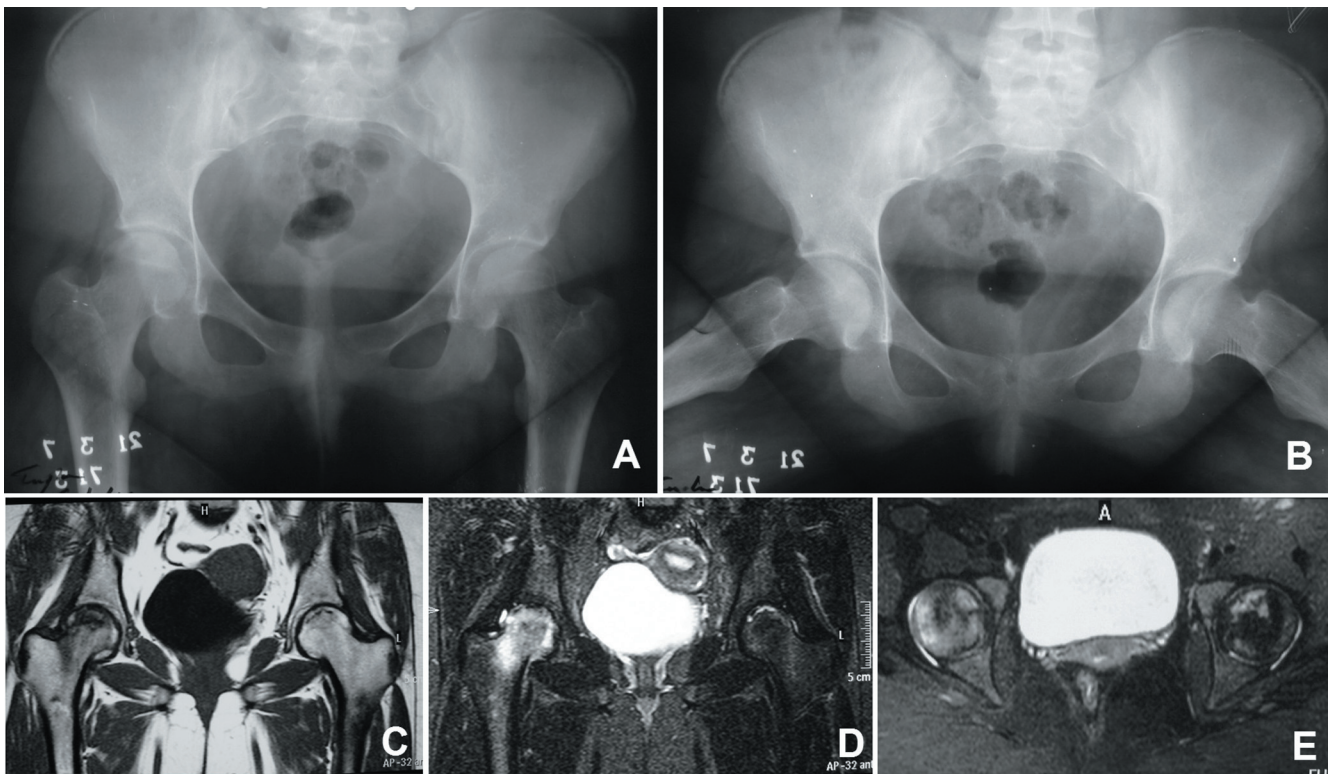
A-E. Anteroposterior (a) and frog-leg (b) radiographs of the pelvis of an 18-year-old female patient (6th patient in Table 1) before the operation show minimal lucent and sclerotic lesions on the right hip with no radiographic changes on the left hip. T1-weighted coronal MRI scan (c) demonstrates low signal intensity in the superior weight-bearing area of the right femoral head. There is also a low signal intensity rim in the proximal aspect of the left femoral head. T2-weighted coronal (d) and axial (e) MRI scans show high signal intensity of the entire right proximal femur and also high signal intensity line in the superior part of the left femoral head.
